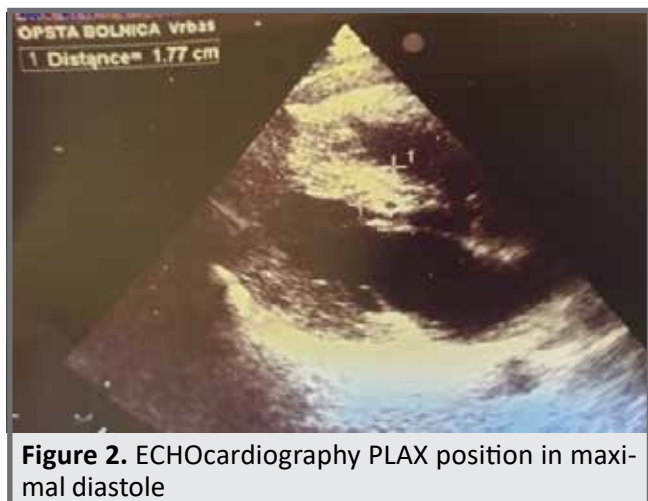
ECHOCARDIOGRAPHY PLAX position in maximal diastole
